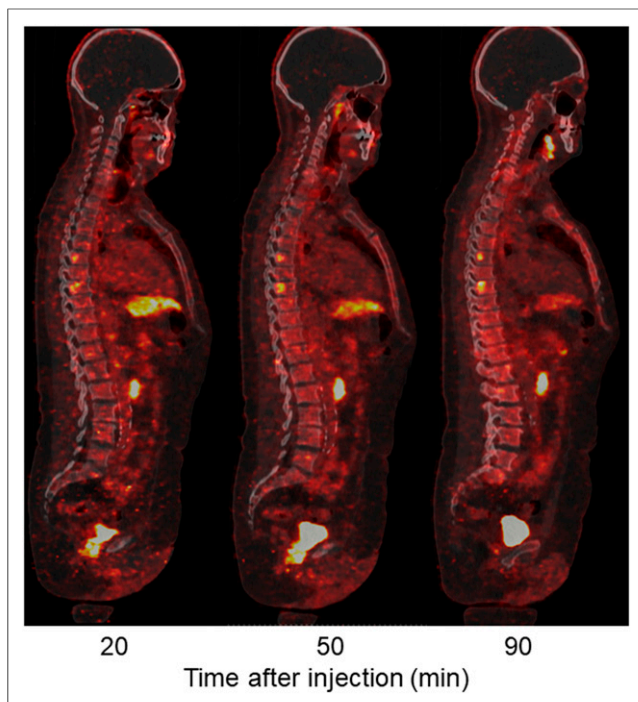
Low-dose PET/CT sagittal images of bone window. Two possible bone lesions can be detected at T6 and T8, as well as local recurrence in prostate bed.
